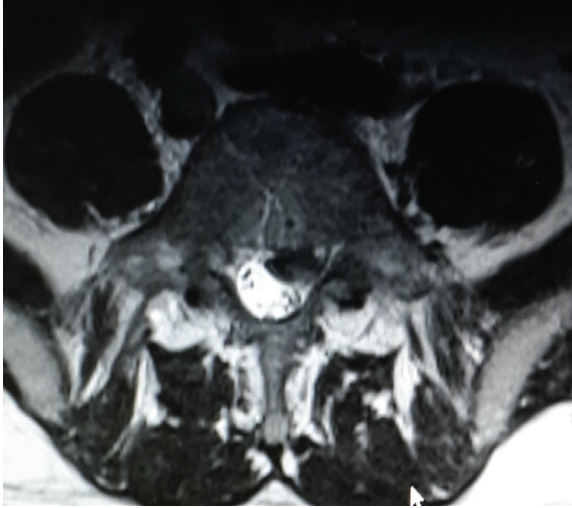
Axial T2-weighted MRI demonstrating a large sequestered left-sided paracentral disc fragment at the L4-5 level (pain relievers, muscle relaxants and bed rest were recommended to the patient)
